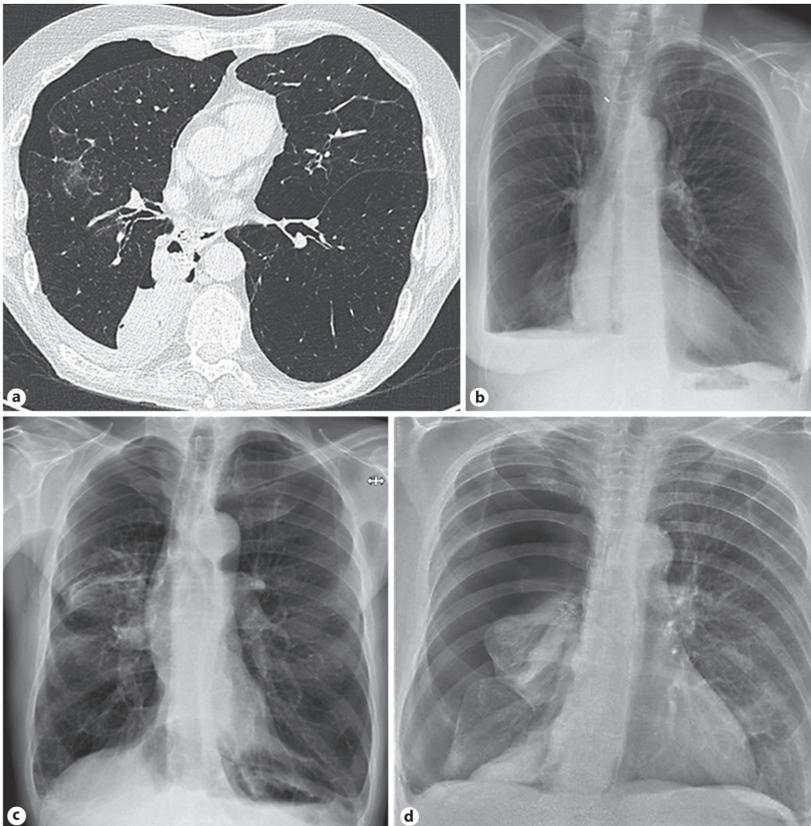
a Pneumothorax ex vacuo on a chest CT scan after valve treatment in the left upper lobe. The patient received no intervention. The pneumothorax was asymptomatic and resolved within 4 weeks. b, c Pneumothorax ex vacuo on chest X-ray. d Complete pneumothorax for which acute intervention is needed.
